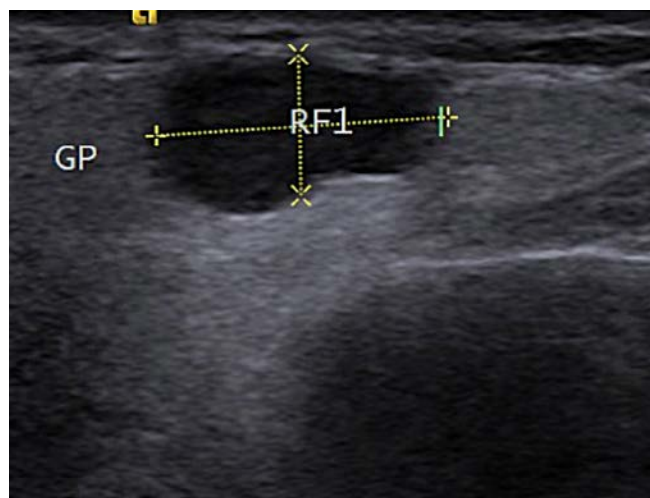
B-mode sonography of the first tumor in the preauricular area of the right parotid gland (2. case, RF1 – first tumor)
